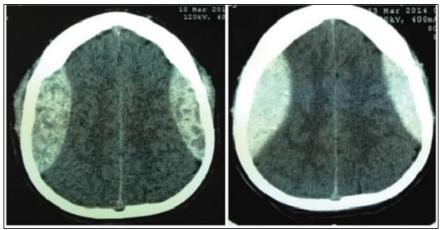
Pt. 56 yrs Male presented to SNMC emergency with GCS 10 due to RTA. (a) EDH volume 30 ml in left frontoparietal region (b) CT repeated after 2 days showing resolving hematoma. (c) CT repeated after 21 days hematoma resolved further with improving GCS
